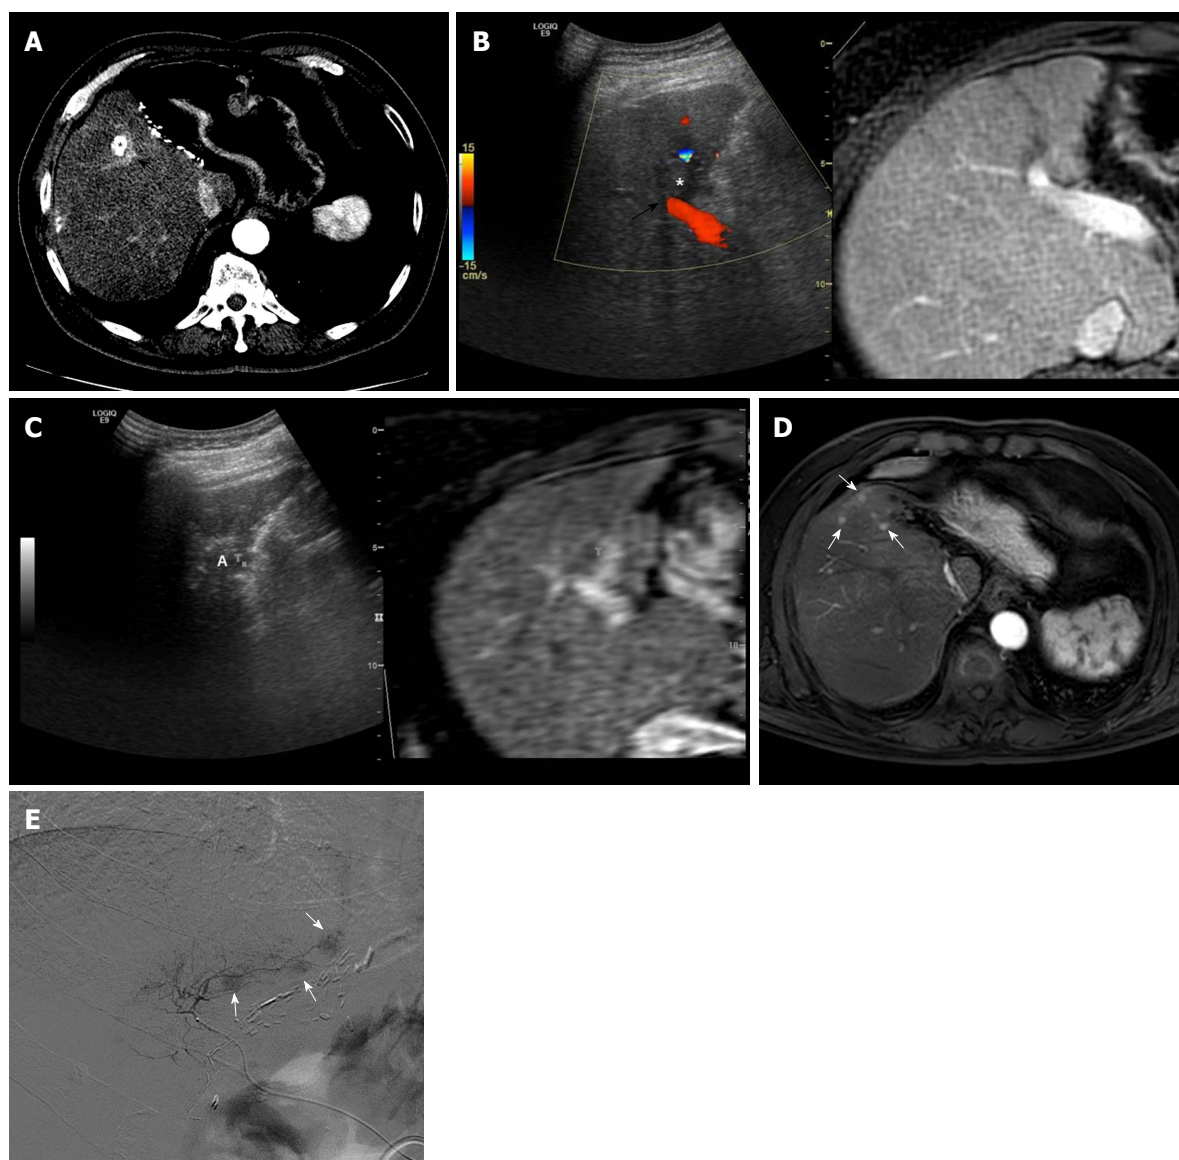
Images demonstrating aggressive intrasegmental recurrence after radiofrequency ablation for perivascular hepatocellular carcinoma. A: Axial computed tomography image obtained during hepatic arterial phase shows viable hepatocellular carcinoma (HCC) within the partially lipiodolized nodule (asterisk) in segment V before radiofrequency (RF) ablation. The index tumor is in contact with the right portal vein (black arrow); B: On planning ultrasonography (US), using fusion imaging with color Doppler US and magnetic resonance imaging (MRI), the low echogenic incident tumor (asterisk) is in contact with a right portal vein (black arrow); C: During RF ablation with the US fusion system, the ablation zone (A) is covered with viable enhancing tumor foci, indicating T marker on real time US/fused MR image; D: MRI scan obtained during the hepatic arterial phase 9 mo after RF ablation shows multiple small arterial enhancing nodules (white arrows) of consistent size, representing recurrent tumors. These recurrent tumors developed simultaneously in a peripheral area of the treated segment, fed by the previous peritumoral portal vein; E: The patient underwent transarterial chemoembolization for tumor control considering tumor multiplicity. Multiple small nodular tumors were detected along the portal tract on hepatic angiogram.
